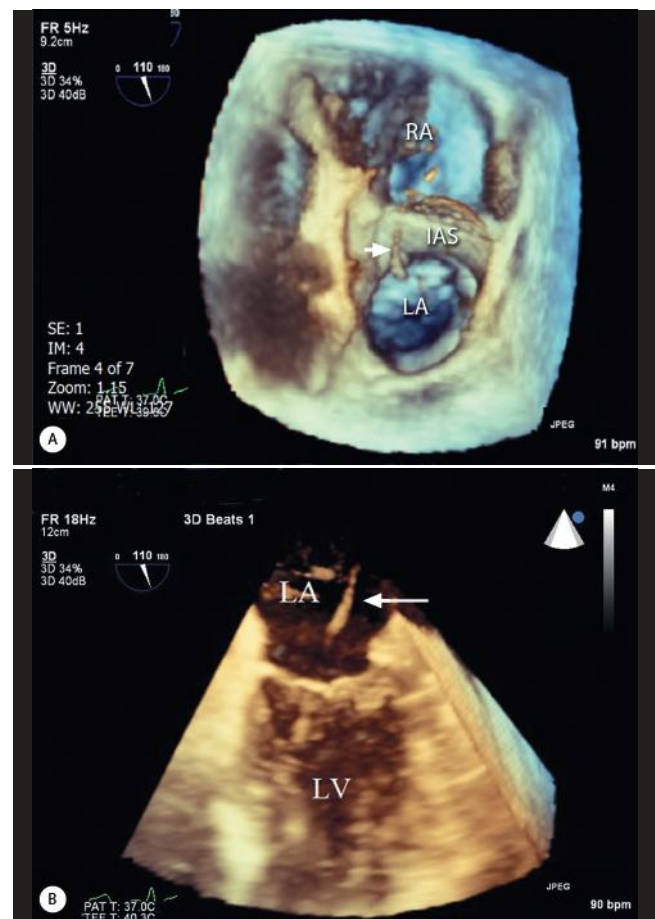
Three-dimensional transesophageal echocardiography
